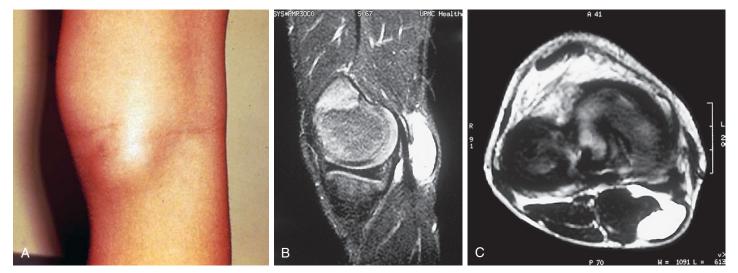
Popliteal (Baker) cyst. A, A localized swelling appears in the region of the semimembranosus tendon. This may arise from the synovial lining of the semimembranosus bursa. B, Sagittal plane magnetic resonance imaging (MRI) from another child with a Baker cyst shows the posterior location. C, A transverse plane MRI demonstrates the posterior and medial position of cyst and its close relation to the gastrocnemius muscle.
